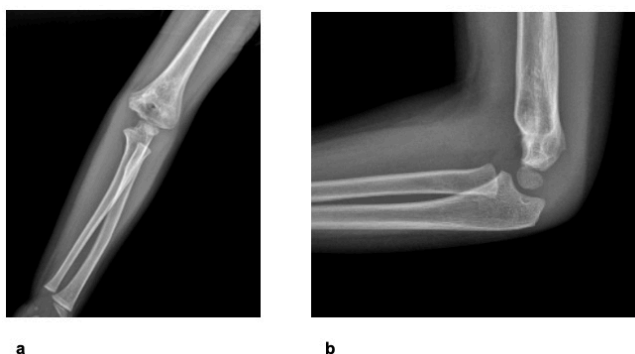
A-P radiography of pediatric supracondylar humerus fracture three years later, b: Lateral radiography of pediatric supracondylar humerus fracture three years later
